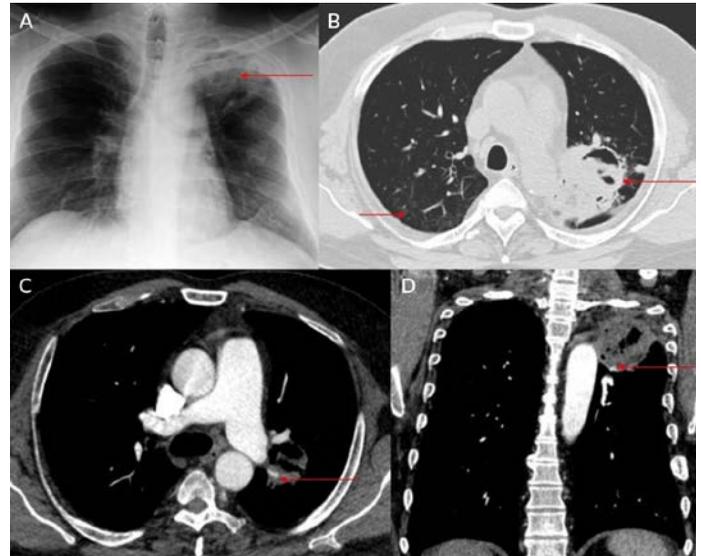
Glue embolization. (A) Chest X-ray posteroanterior view showing cavitation with surrounding changes of consolidation involving the left upper zone. (B) High-resolution computed tomography chest axial image showing cavitation with internal debris and surrounding areas of consolidation involving the left upper lobe. (C) and (D) Axial and coronal images showing a small pseudoaneurysm involving the upper lobe apicoposterior branch of the left pulmonary artery.
